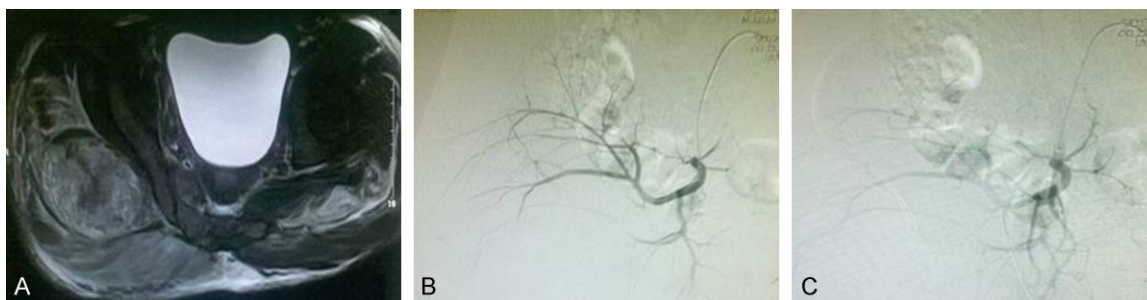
A is the general range of tumors by the preoperative MRI examination. B is the preoperative arteriography. C is the selective arterial embolization.
